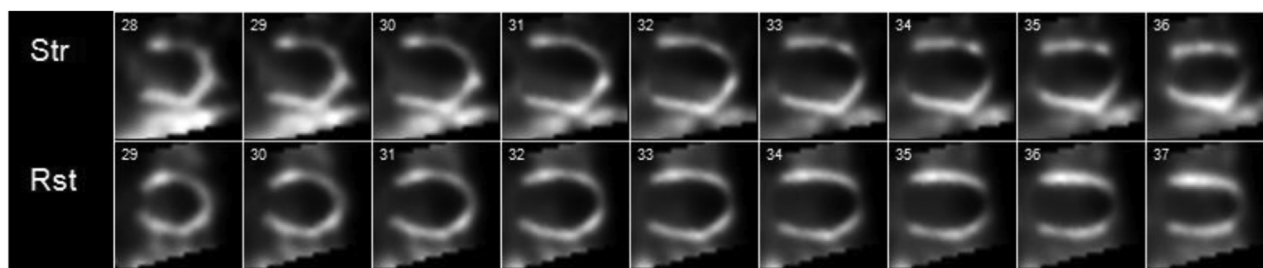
Vasodilator (regadenoson) stress (*top row*) and rest (*bottom row*) technetium myocardial perfusion imaging single-photon emission computed tomography imaging, vertical long-axis orientation, demonstrates a dilated LV with a large reversible perfusion deficit in the mid-distal anteroseptal, anterior, anterolateral, and apical walls.
